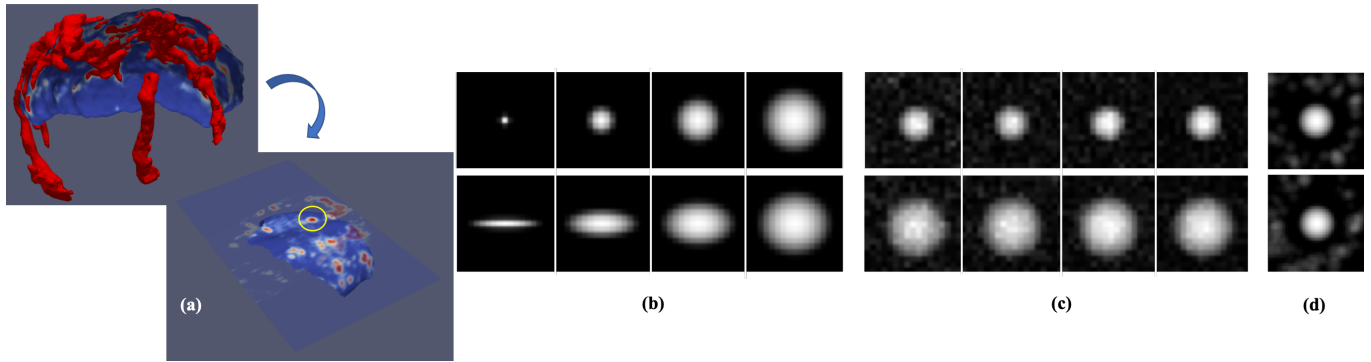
Vessel sections in real (a) and synthetic images (b)-(d). (a) Real Doppler signal distributed on the surface at 1 mm away from the UPI into the placenta, the yellow circle indicated an individual vessel cross-section based on which a cutting plane was created; (b) Examples of 'noise free' synthetic images representing various vessel shapes, circular (up, radius $r = 0.5, 1.5, 2.5, 3.5$ mm) and elliptical (bottom: major semi-axis $a = 4$ mm and minor semi-axis $b = 0.5, 1.5, 2.5, 3.5$ mm) in $10 \text{ mm} \times 10 \text{ mm}$ images. (c) Examples of synthetic vessel sections with different radii (up: $r = 2$ mm; bottom: $r = 3.5$ mm) and SNR = 9, 10, 11, 12 dB from left to right; (d) Two examples showing clutter noise around a major vessel of radius 4 mm.
